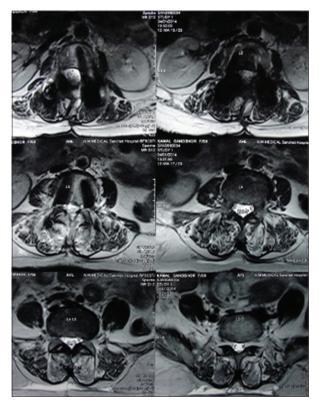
MRI of spine showing resolution of abscess and paravertebral collections.
